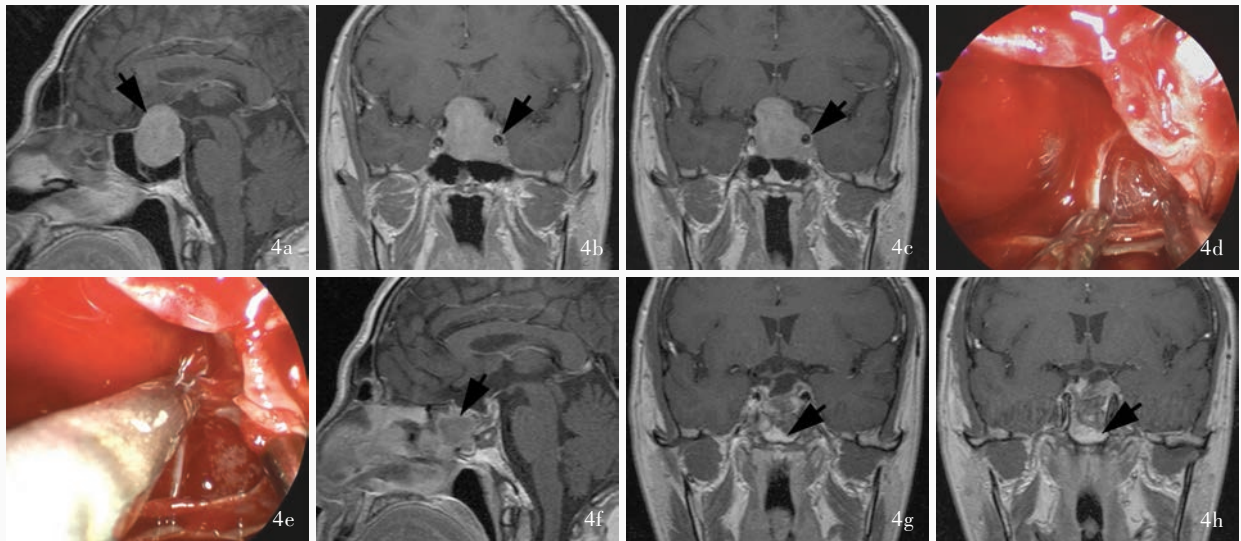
女性患者, 62 岁, 临床诊断为无功能性垂体腺瘤 (Knosp 分级 3B 级)。手术前后鞍区 MRI 和术中内镜所见 4a 术前矢状位增强 T₁WI 显示肿瘤呈类圆形不均匀强化 (箭头所示), 视交叉上抬, 垂体窝扩大 4b, 4c 术前冠状位增强 T₁WI 显示, 肿瘤呈不均匀强化, 侵袭性生长, 左侧颈内动脉壁受累 (箭头所示) 4d 术中内镜下可见肿瘤呈侵袭性生长, 一侧海绵窦前下间隙受累, 肿瘤突破海绵窦内侧壁, 侵入海绵窦 4e 术中内镜下可见海绵窦侧壁裂口, 切除肿瘤后显示海绵窦内分隔组织结构 4f 术后矢状位增强 T₁WI 显示肿瘤基本全切除, 代替为填充物, 最外侧黏膜瓣呈均匀强化征象 (箭头所示) 4g, 4h 术后冠状位增强 T₁WI 显示肿瘤基本全切除, 代替为填充物, 最外侧黏膜瓣呈均匀强化征象 (箭头所示)
